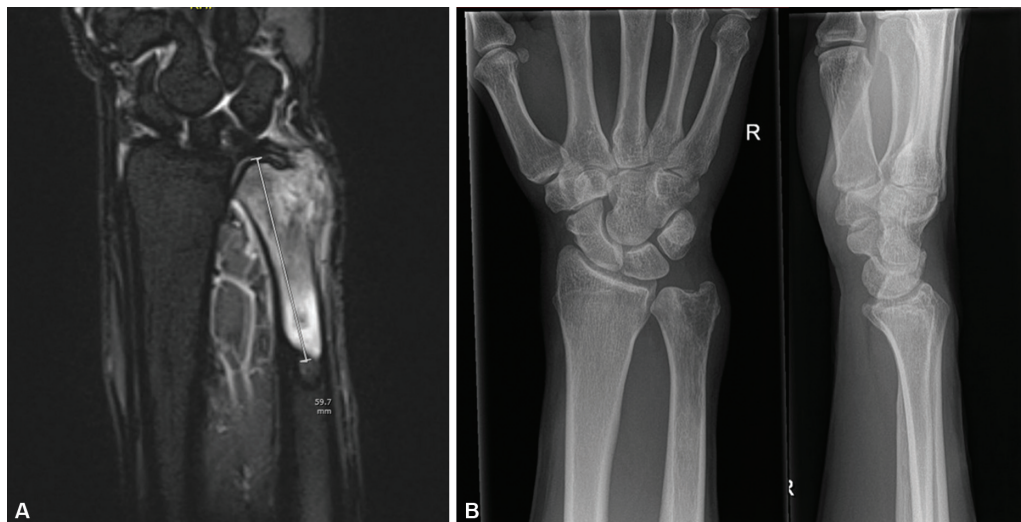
(A) Preoperative MRI scan Case 1, note the appearance of the leiomyosarcoma (59,7 mm) in the end of the right distal ulna. (B) Preoperative anteroposterior and lateral X-rays of Case 1 before placement of the Aptis implant.
